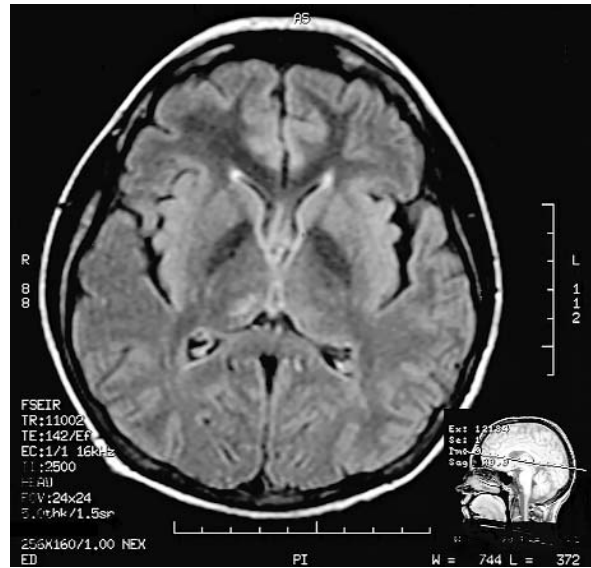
FLAIR showing the third ischemic focus in the right thalamus
